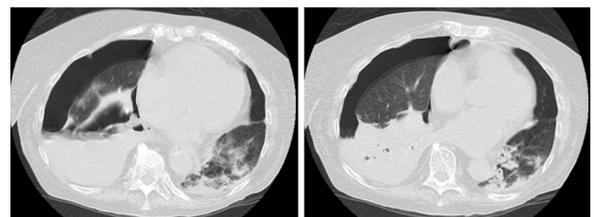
Transversal CT slices of the chest performed on day 23 of admission, showing right hydropneumothorax, right lower lobe atelectasis and areas of consolidation, some cavitary, mainly in the right lung base. Cavitary pulmonary nodules and ground-glass opacities adjacent to the area of consolidation can be seen in the left lower lobe.
